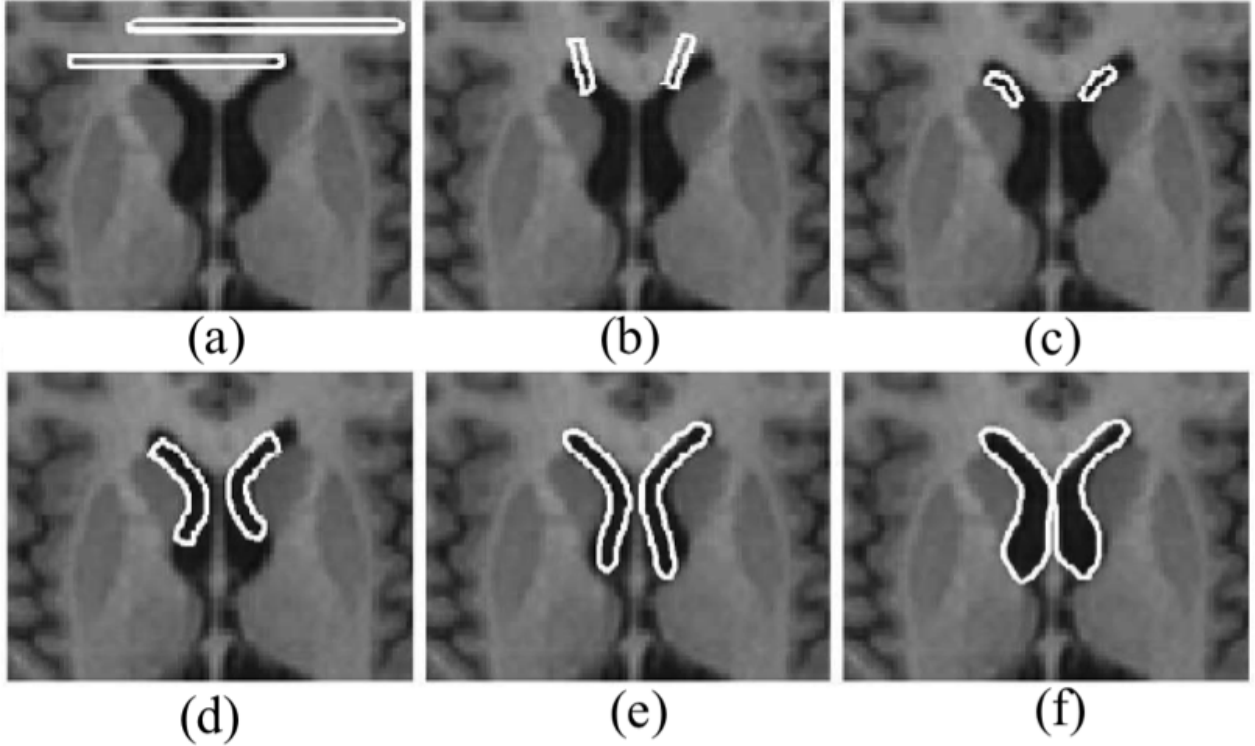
Automatic MR image segmentation of lateral ventricle by deformable model. (a) initial contours ; (b-e) intermediate results of contour deformation ; (f) final result (McInerney et al., 2002).
